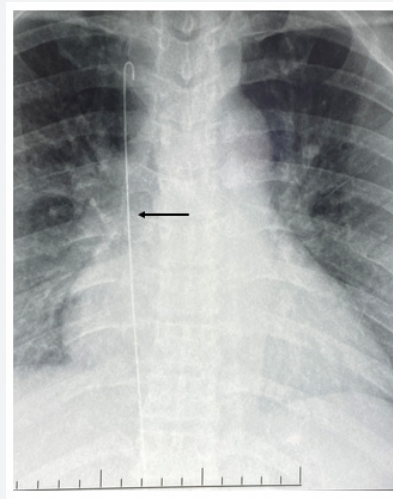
Front chest x-ray showing the migration of the metal guide intracardiac through the inferior vena cava.
